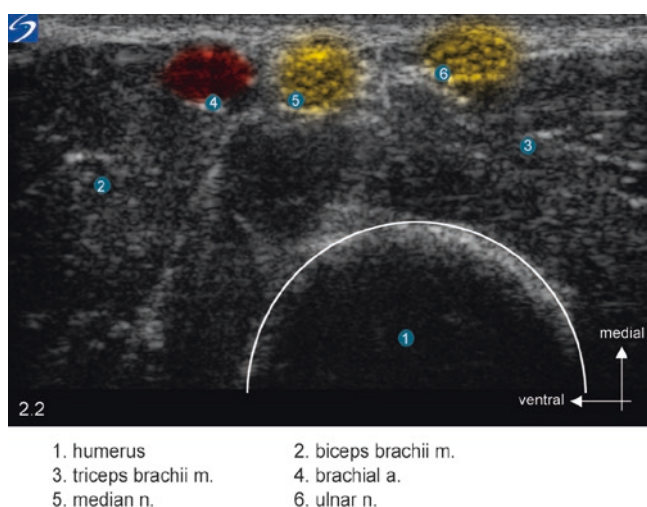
Transverse ultrasound section in the brachial canal displaying the median nerve posterior to the artery while the musculocutaneous and radial nerves no longer appear in the field
